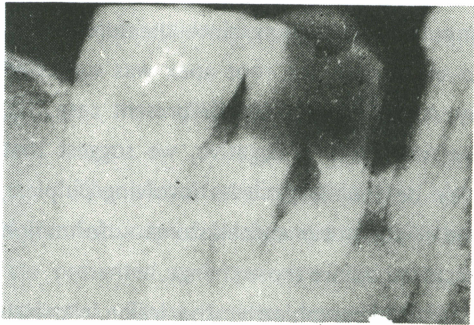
Periapical view: radiopaque mass around the mesial root of 6 .
